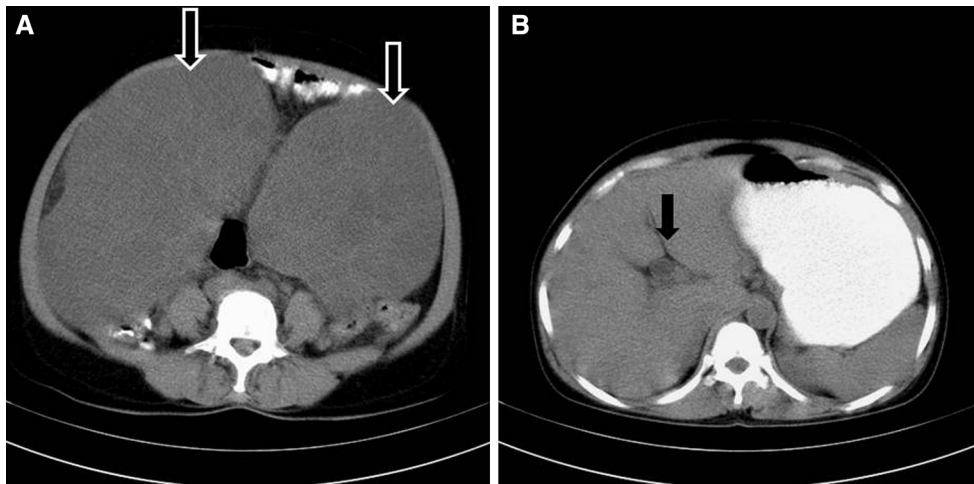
a Computerized tomogram (CT) of abdomen showing two large heterodense masses (*arrows*) arising from ovaries; b CT showing a hypoechoic space occupying lesion in gall bladder (*arrow*)
